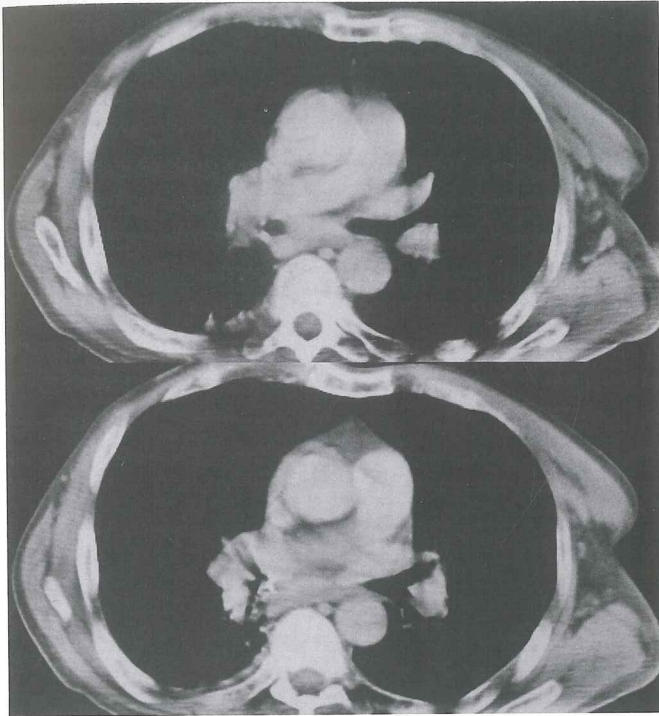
Thorax CT of the patient showing a mass lesion partially obstructing right intermediate bronchus.
